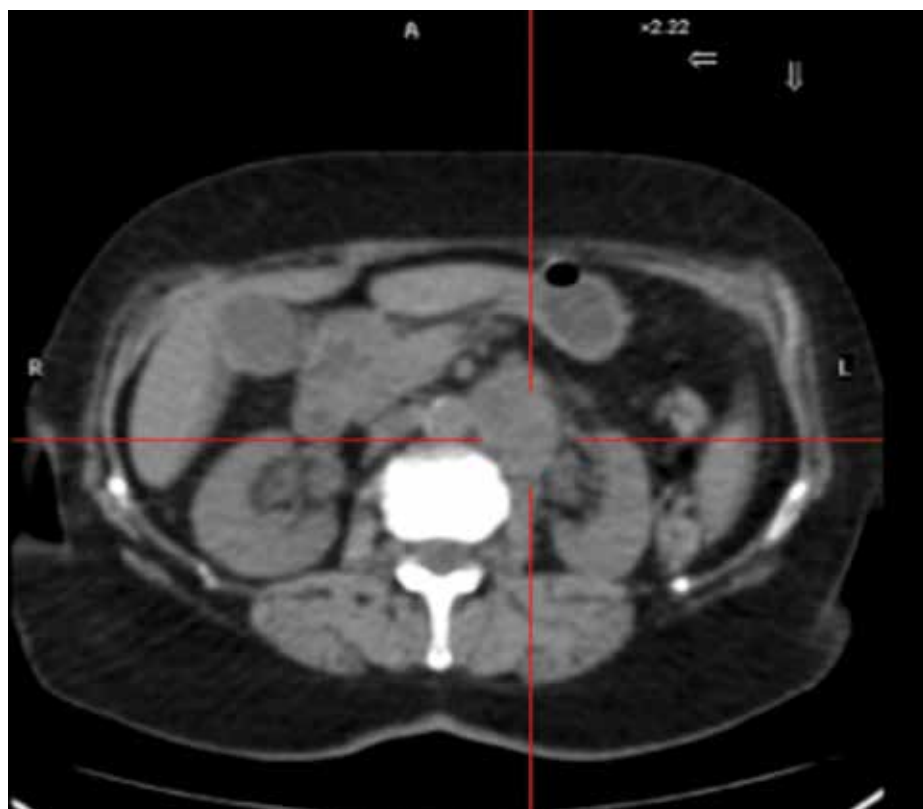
Computed tomography (axial) shows retroperitoneal paraaortic mass of 52x35x61 mm at the level of the left renal hilum with intratumoral central necrosis, suggestive of malignancy
